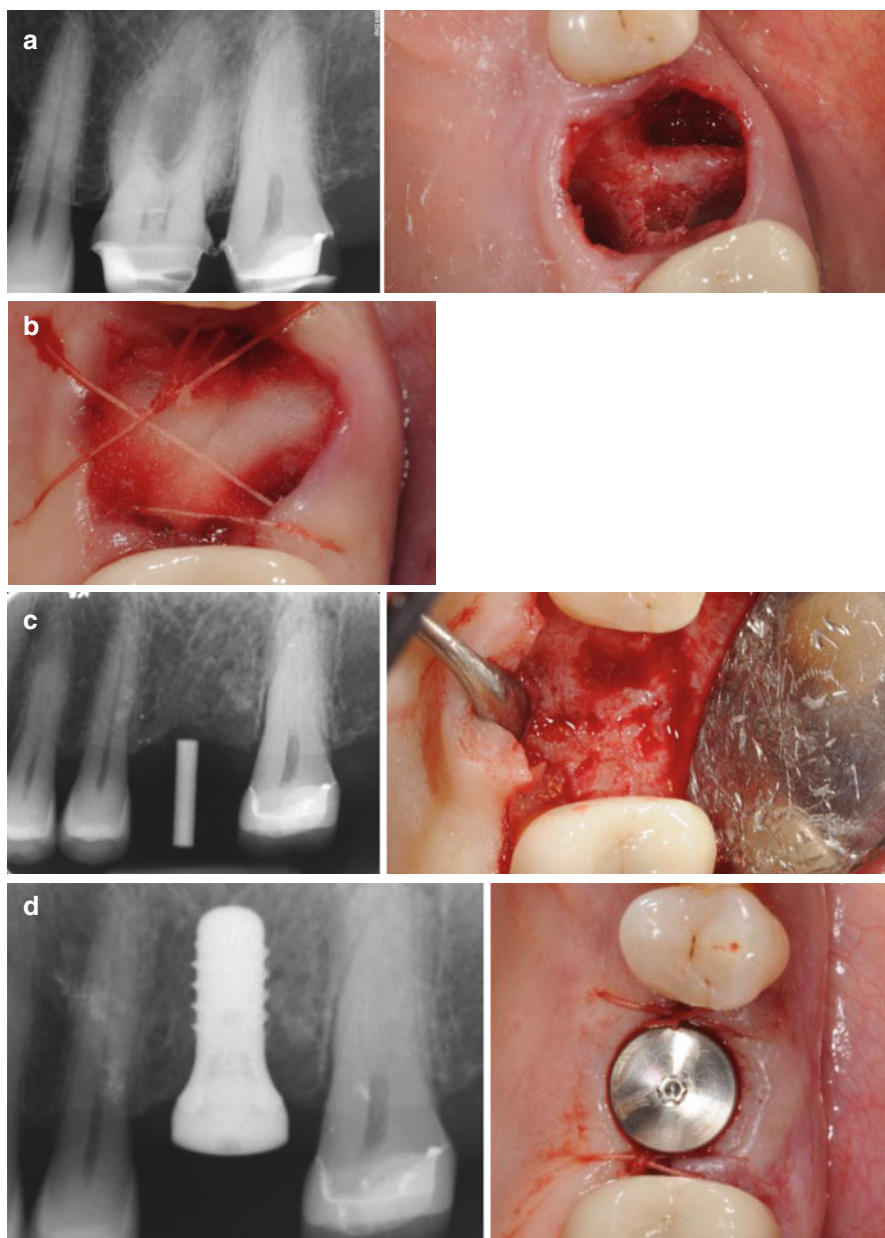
(a) Tooth extracted due to a longitudinal root fracture diagnosed during an attempt to endodontically treat the tooth. (b) Ridge preservation done with freeze-dried bone allograft (FDBA) bone substitute and collagen membrane. (c) Implant placement 6 months after extraction and ridge preservation. (d) Postoperative radiograph and photo of the implant
